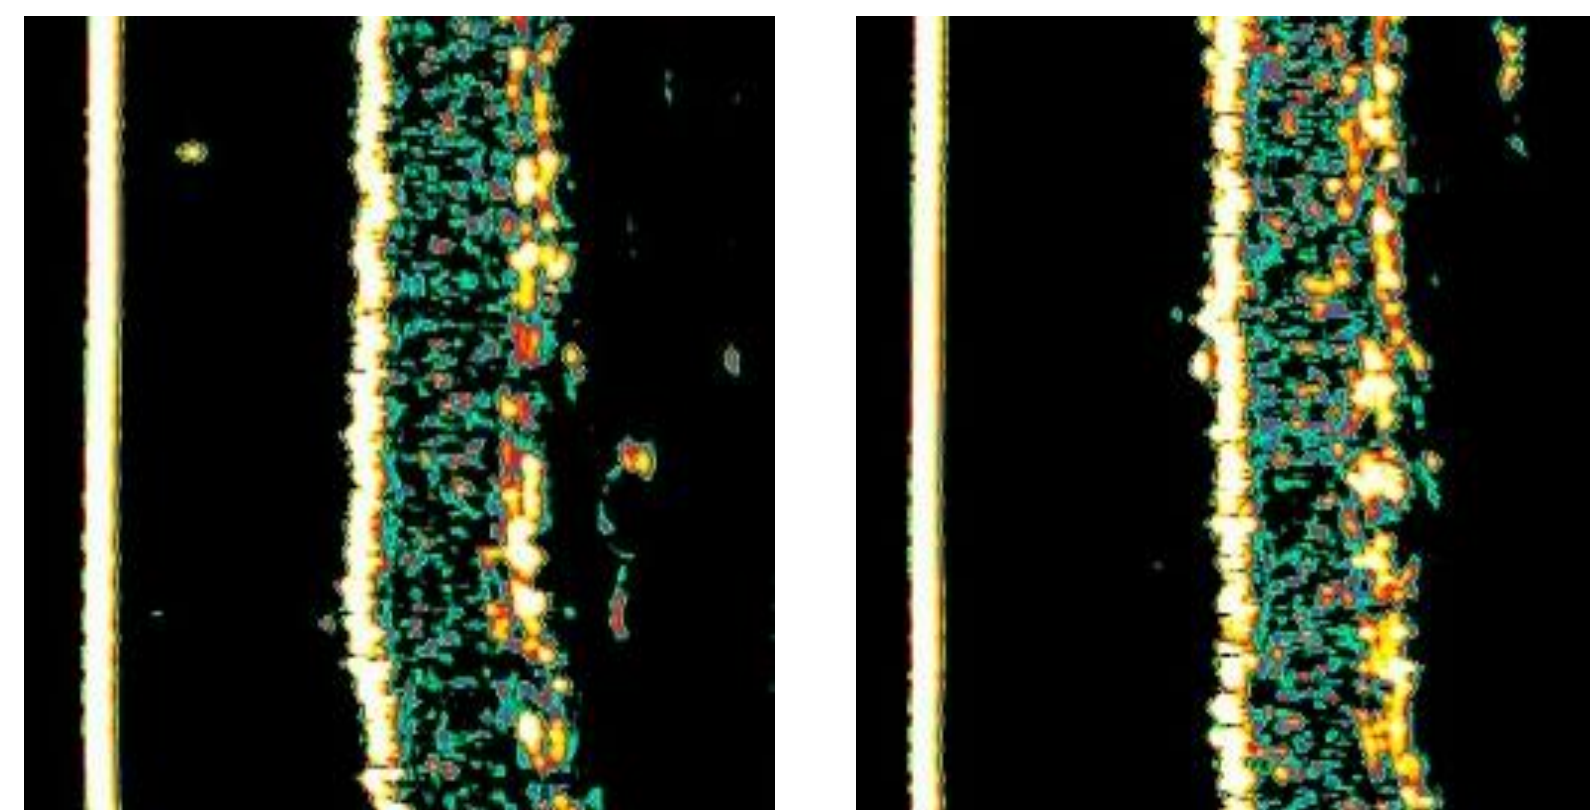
High frequency ultrasound images: Lighter colours correspond to a strong reflection and dark colours to a weak reflection. This way slight differences in the reflection behaviour and in tissues can be made visible by the colour representation.
